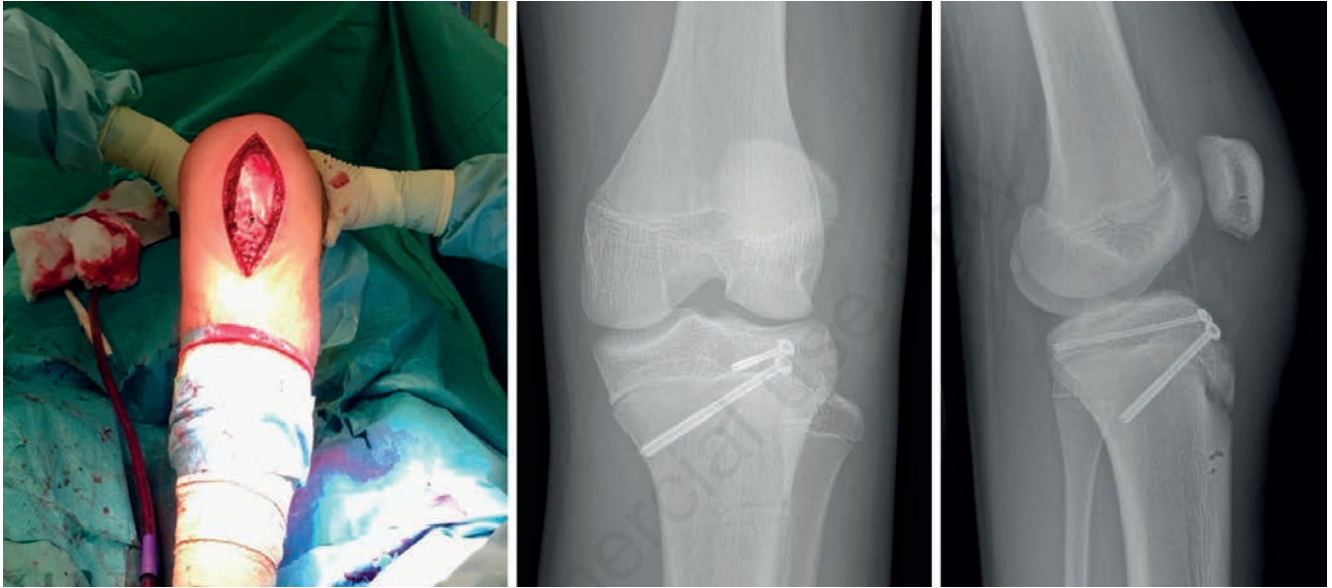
Intraoperative image (left) of the patellar tendon repair through the Krakow technique with 2 high resistance sutures. AP (middle) and lateral (right) postoperative radiographs showing correction of the patella height.
